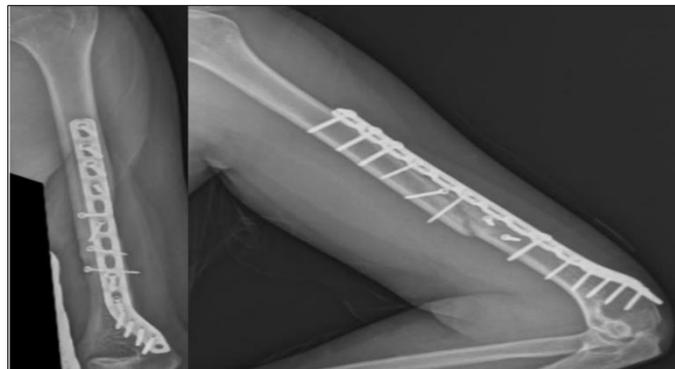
Postoperative radiograph at 6 weeks of follow up
